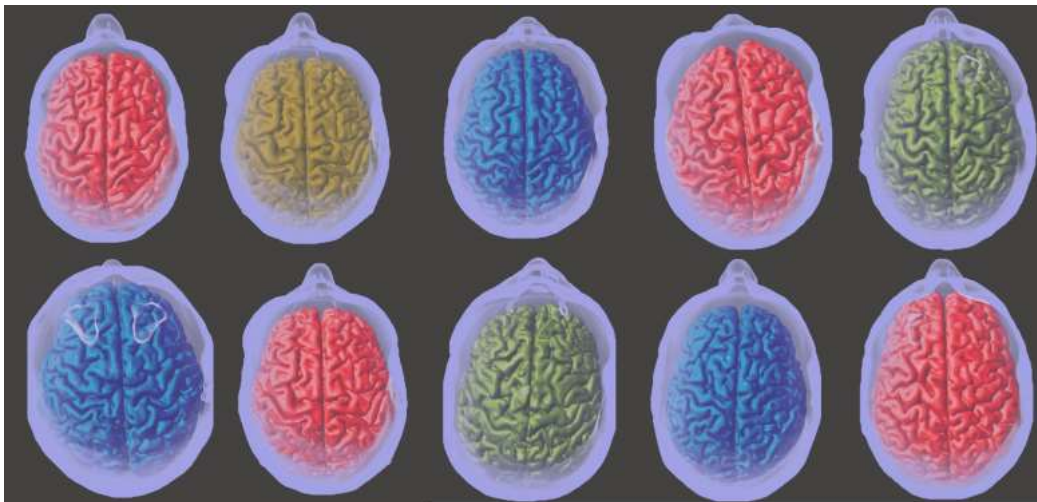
Anatomical Variation. Head models from each participant are visualized (participant ID. 1-10, from top left, across, then to bottom left and across). Each head model is distinct and made to the MRI of an individual participant.
